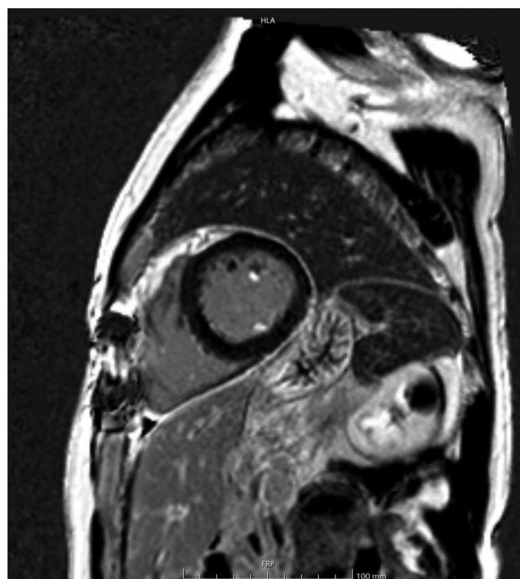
heart MRI performed one year after emergency aortic valve surgery, showing normal native T1 and extracellular volume (ECV) values, no edema in T2-weighted images and absence of late gadolinium enhancement.
